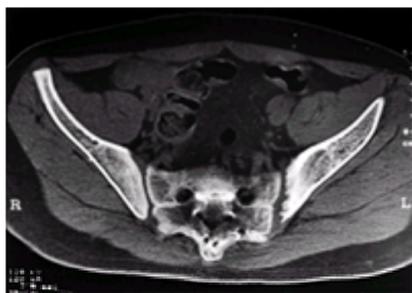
CT scan of the SI joints in a child with juvenile ankylosing spondylitis, showing erosions and sclerosis of the SI joints. (Courtesy of Dr. Ruben Burgos-Vargas.)
